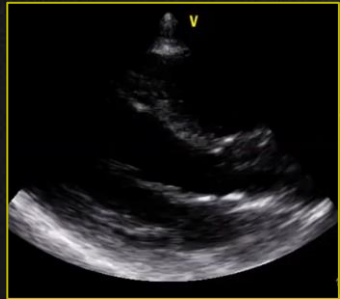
parasternal long axis (PLAX) view.
